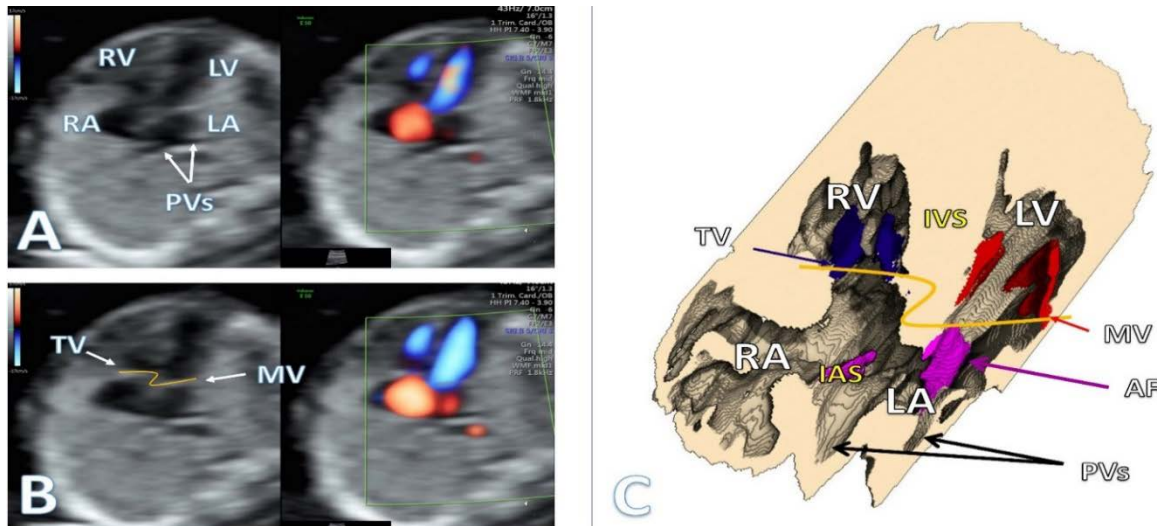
Four-chamber view comparison. A. Ultrasound four chamber plane showing the pulmonary veins entering the left atrium; B. Ultrasound image of the four-chamber view with closed atrioventricular valves-normal offset of the valves, with the tricuspid valve inserted higher than the mitral valve; C. Three-dimensional volume slice similar to the four-chamber view revealing the offset of the atrioventricular valves and the pulmonary veins drainage into the left atrium.
